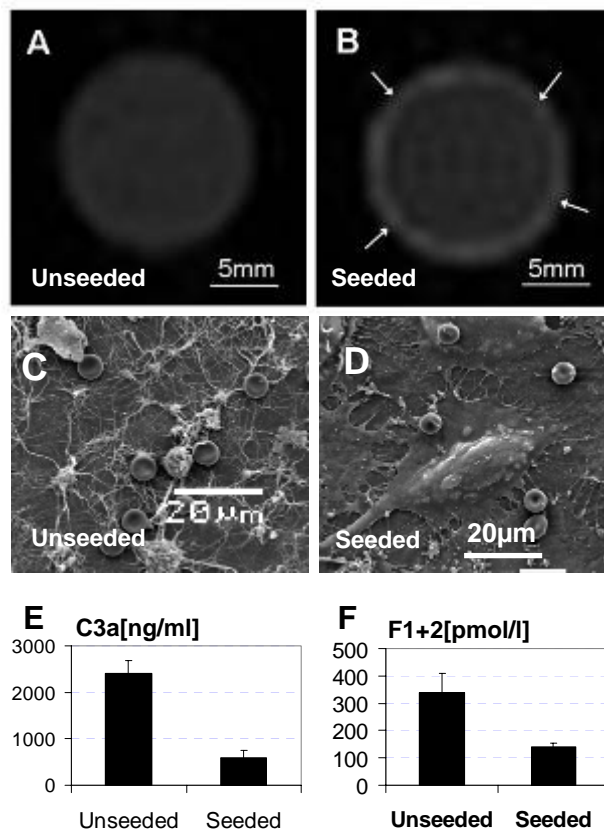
MRI inspection of unseeded (A) and seeded (B) vascular grafts. The endothelium appears as a bright layer on the lumen of the graft (arrows). Unseeded grafts trigger platelet activation and fibrin formation (C). Endothelialised grafts inhibit coagulation (D). Endothelial cells inhibit the thrombogenic properties of synthetic grafts (E, F).
